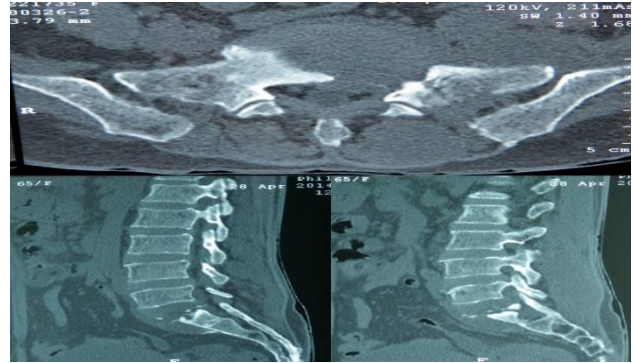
CT scan depicting the extent of destruction of sacrum.
